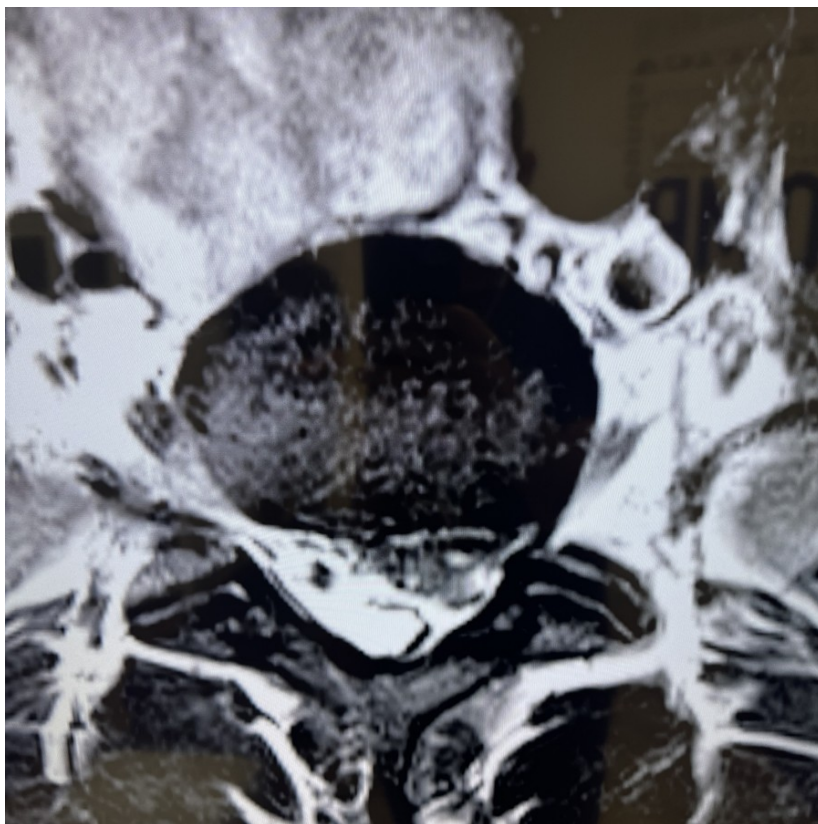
Pre-treatment axial MRI image at the L5-S1 intervertebral disc level demonstrating the disc protrusion. Posterior disc protrusion with encroachment on the spinal canal is noted, consistent with the patient's clinical presentation of low back pain, left leg numbness, and sciatica radiating to the left calf.
